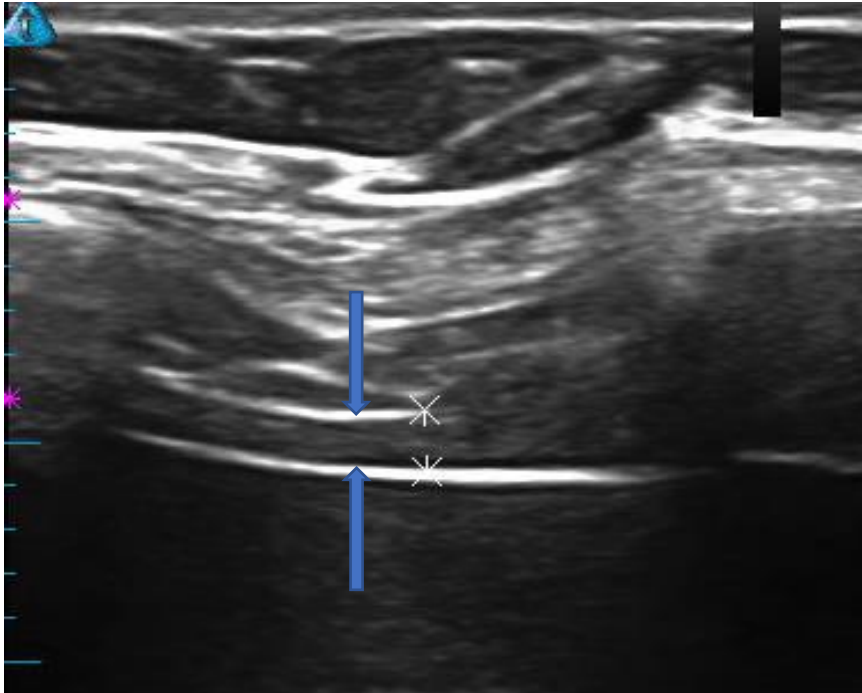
Ultrasound image of the diaphragm thickness in the zone of apposition
